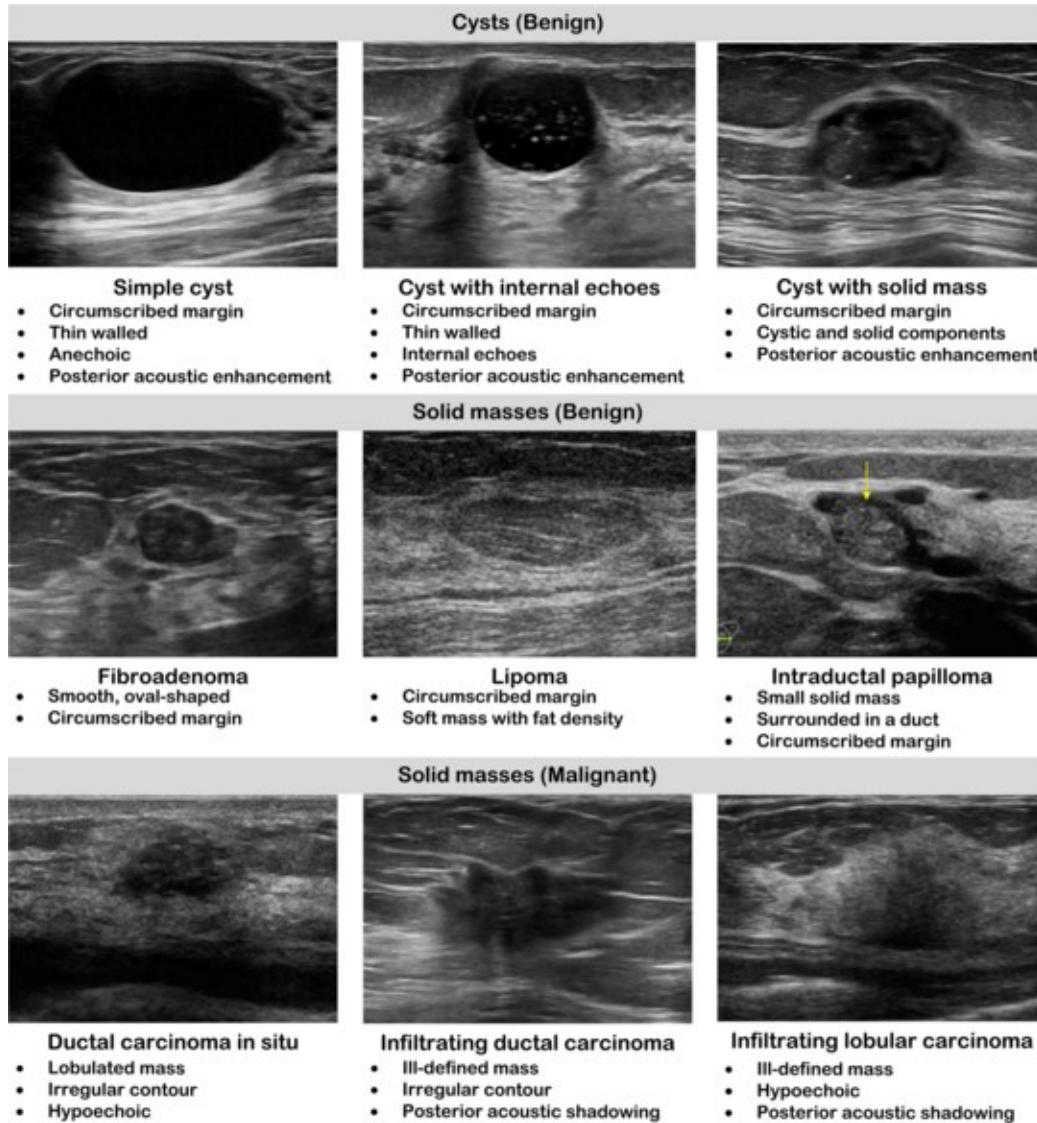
Sample ultrasound images indicating sonographic characteristics exhibited by breast abnormalities.
